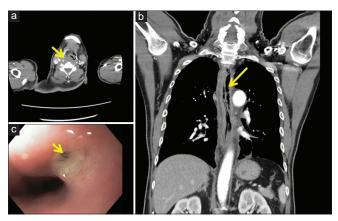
(a) Computed tomography – Abscess in the right pyriform sinus. (b) Computed tomography – Entire esophageal wall was swollen with intramural air. (c) Esophagoscopy showed a right pyriform sinus mucosal perforation with pus
